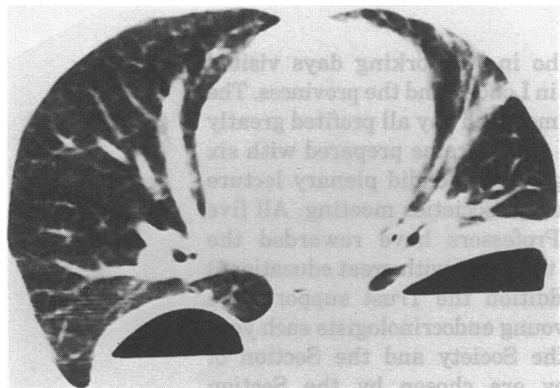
Computed tomography of the thorax in Boerhaave's syndrome, showing intrapleural fluid collections
